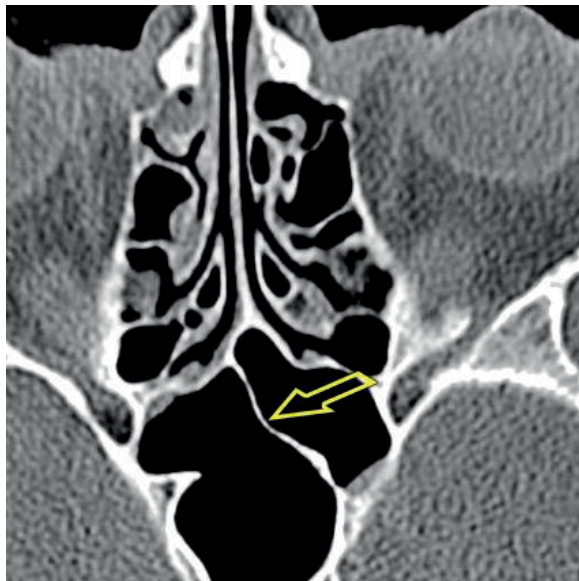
A CT scan of the paranasal sinuses, transverse plane. The shift of both the anterior and posterior parts of the septum to the left.
